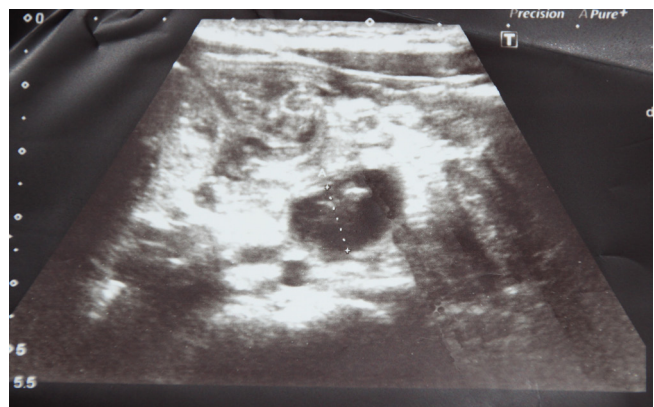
Abdominal ultrasound examination shows dilated small bowel loops with peristalsis partially present, 1 cm diameter non-compressed tubular structure and ascites.
